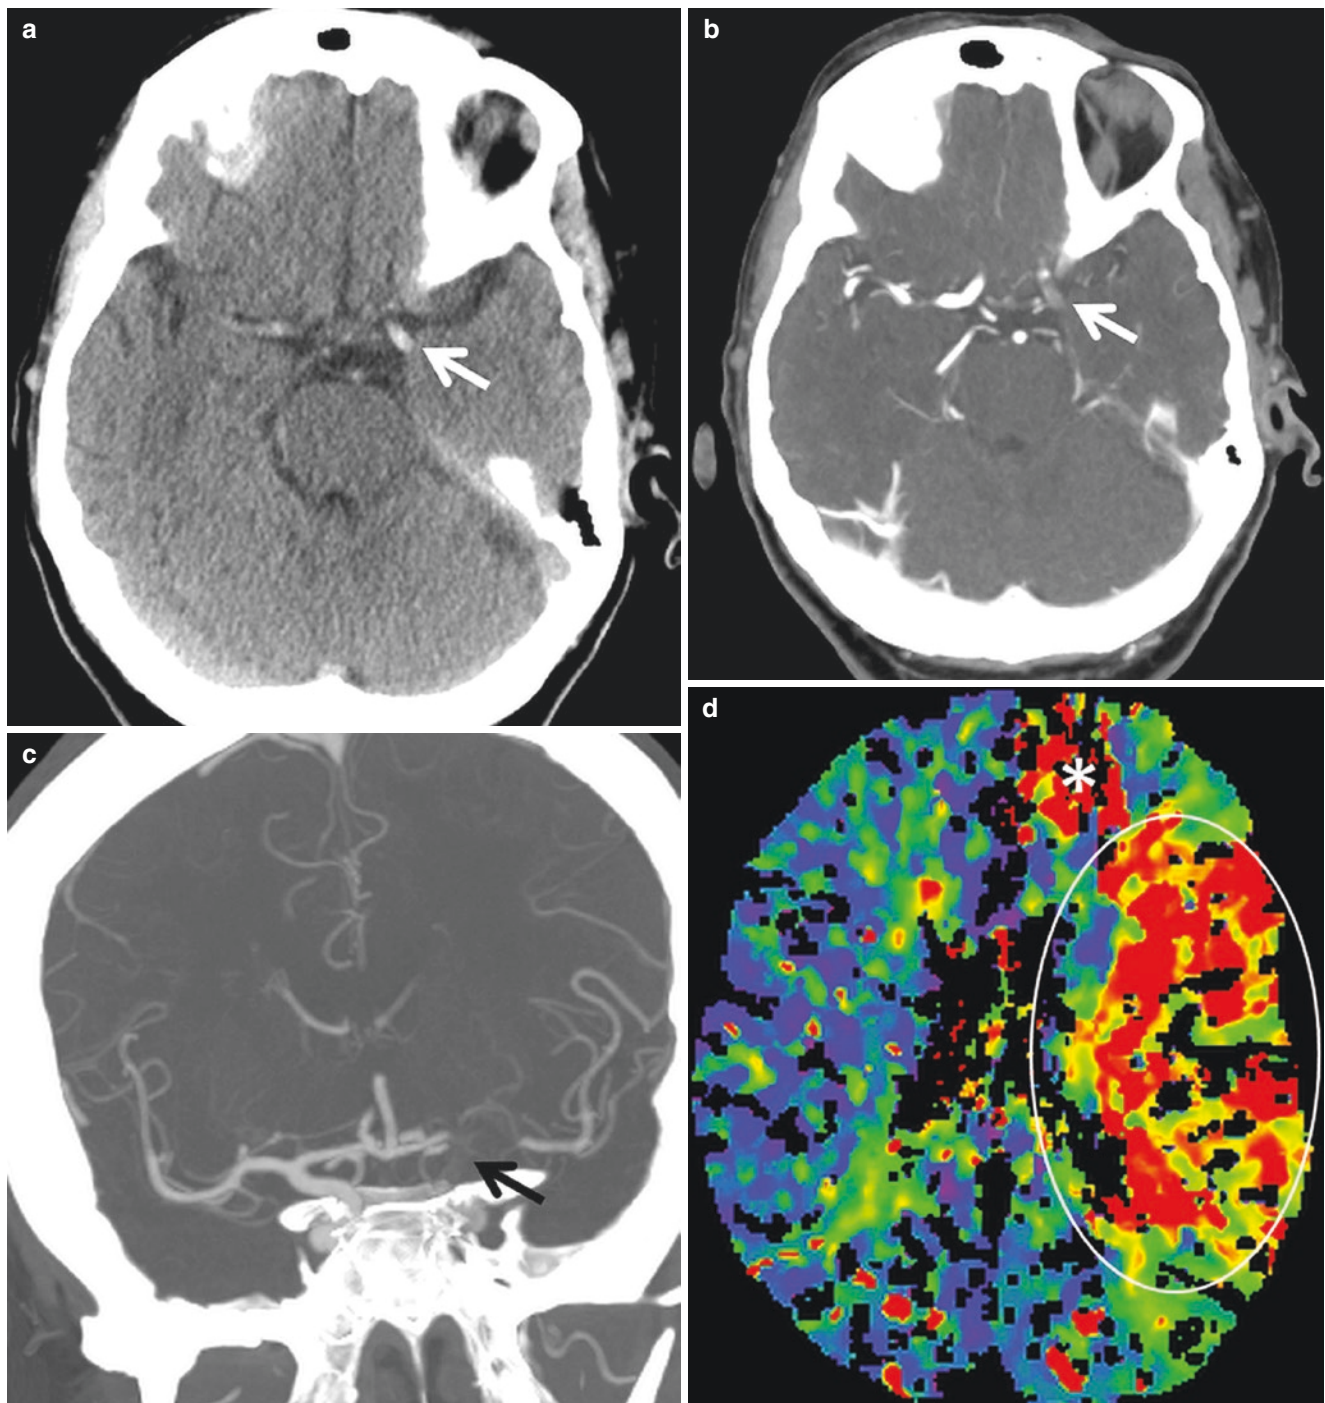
Pattern of small infarction and large penumbra. Patient with sudden-onset right-sided weakness and aphasia. (a), NCCT demonstrates hyperdense left supraclinoid ICA (*arrow*). (b), Axial CTA demonstrates acute occlusion of left supraclinoid ICA (*arrow*). (c), CTA coronal MIP shows occlusion of left supraclinoid ICA, proximal M1 and A1 segment (*arrow*) with distal reconstitution through leptomeningeal collaterals. Perfusion images show prolonged TTD (d), decreased CBF (e), and preserved CBV (f) in the left MCA territory (*circle*), consistent with tissue at ischemic risk (penumbra). A small area in the left
